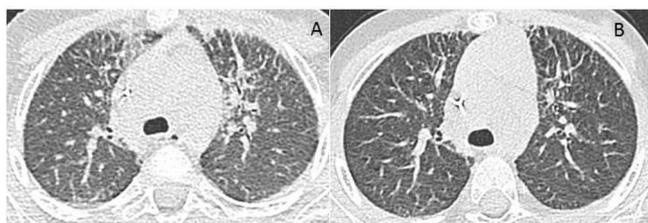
Radiological response to JAK1/JAK2 blockade with ruxolitinib. (A) Chest CT scan before the initiation of ruxolitinib. (B) Chest CT scan 12 months after the initiation of ruxolitinib.
